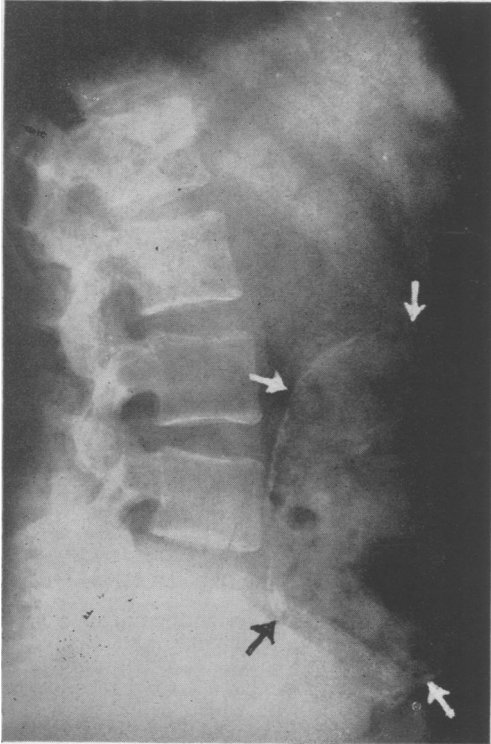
Lateral roentgen ray of the abdomen showing a very large arteriosclerotic aneurysm of the abdominal aorta. Arrows mark the outline of the aneurysm. Note that the calcific wall does not impinge upon the anterior border of the fifth lumbar vertebra.
